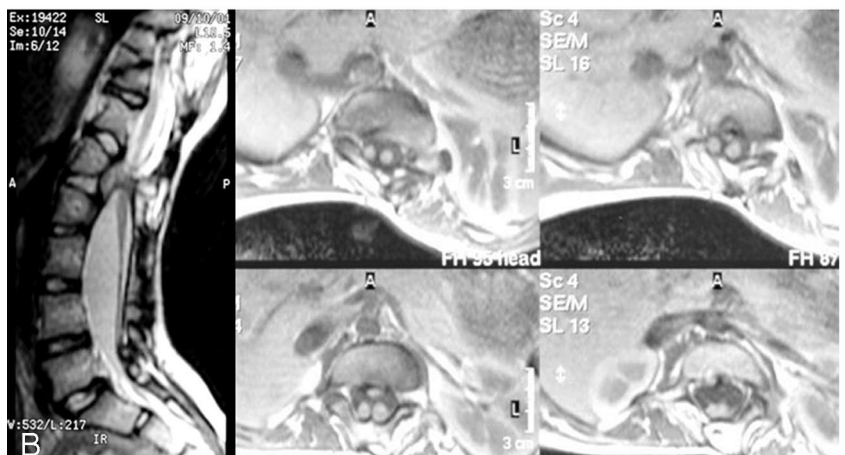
A, A 15-year-old female patient with congenital scoliosis associated with diastematomyelia and tethered cord. After exposure and posterior placement of pedicle screws, tethered cord was released and bony spur was excised. Then, we performed posterior shortening wedge osteotomy at T10–T11 to correct severe frontal imbalance. Two weeks later, anterior fusion was done to prevent pseudarthrosis. At fifth postoperative year, she is free of any symptoms. B, MRI scans showing the diastematomyelia.
